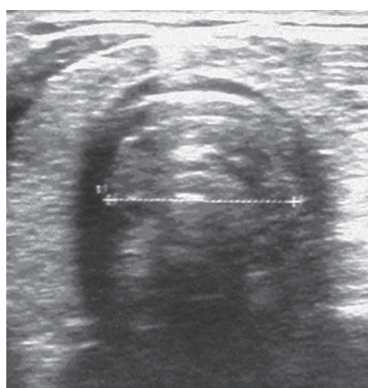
The cricoid arch and the air-column, ultrasonography view. Cricoid cartilage is a round hypoechoic structure (the medulla (A) with hyperechoic edges (the internal (B) and external (C) perichondrium). The air-column (D) appeared hyperechoic and created a posterior acoustic shadow. The mucosa-air interface, a hypoechoic edge, was easily recognized.
